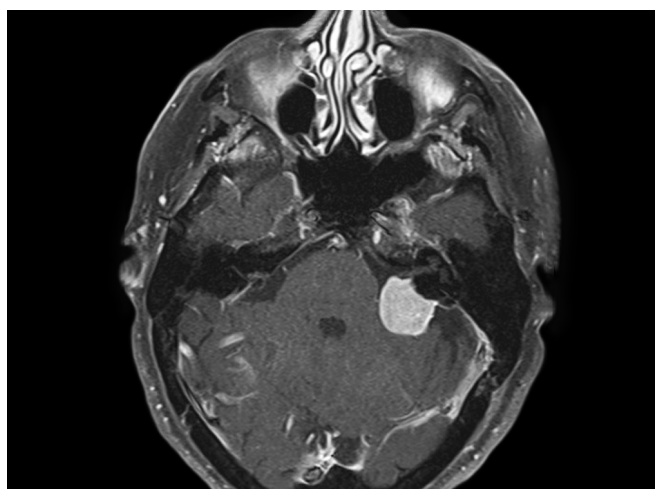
Cerebellopontine angle (CPA) meningioma. Axial T1-weighted gadolinium-enhanced magnetic resonance image (MRI) demonstrating a left cerebellopontine angle meningioma. Note its broad sessile base and dural tail.
